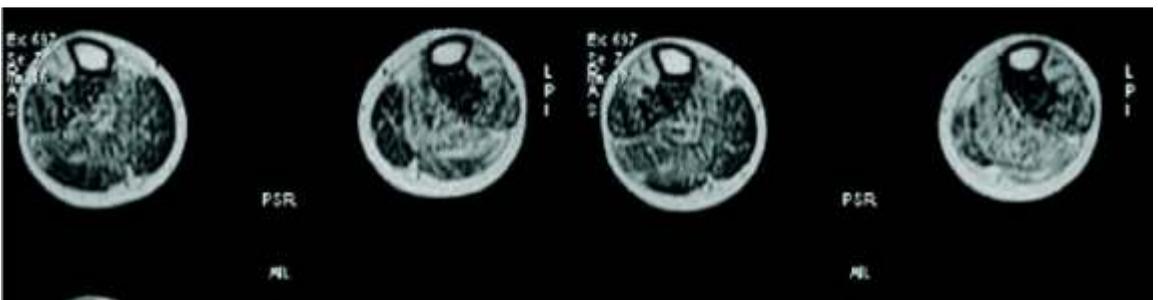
T1 weighted axial musculoskeletal MRI images of Peroneous Longus and Brevis before Autologous BMMNCs transplantation
